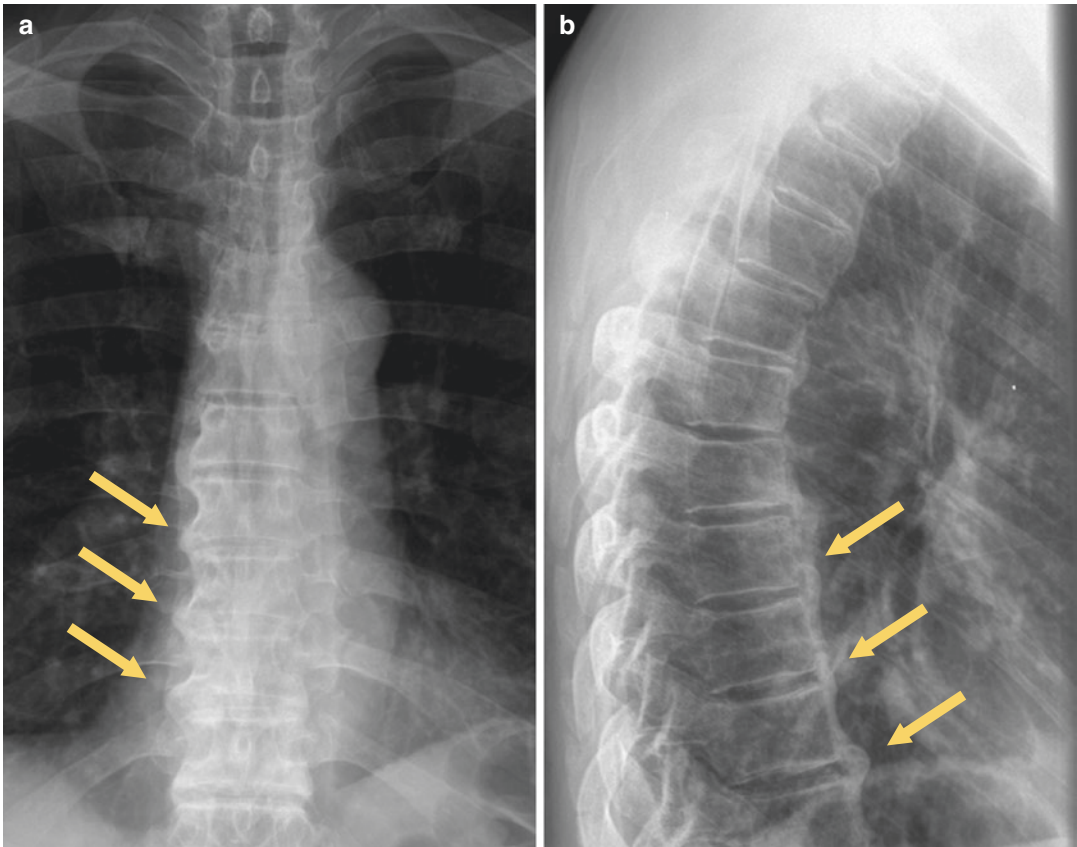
AP (a) and lateral (b) radiographs of the thoracic spine demonstrate the characteristic anterolateral “flowing ossifications” (arrows) representing DISH
